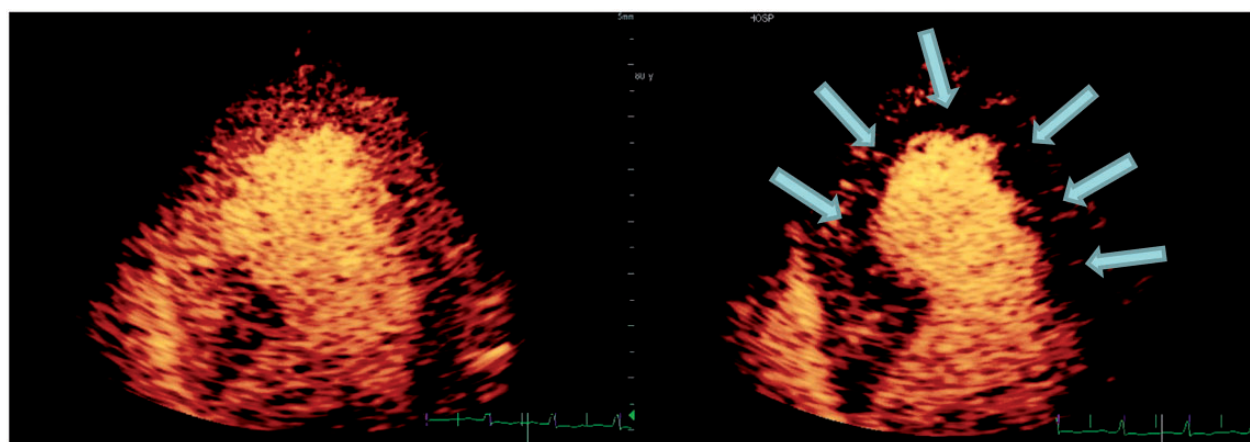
Apical four-chamber view at rest (left) demonstrating normal myocardial perfusion at rest (5 s after myocardial contrast destruction). Right, after stress, four-chamber view displayed 3 s after myocardial contrast destruction. Note sub-endocardial perfusion defect in the septum, apex and transmural defect in the lateral wall. This suggests moderate LAD and severe LCx flow-limiting stenosis, which was confirmed by coronary arteriography.¹³⁴
